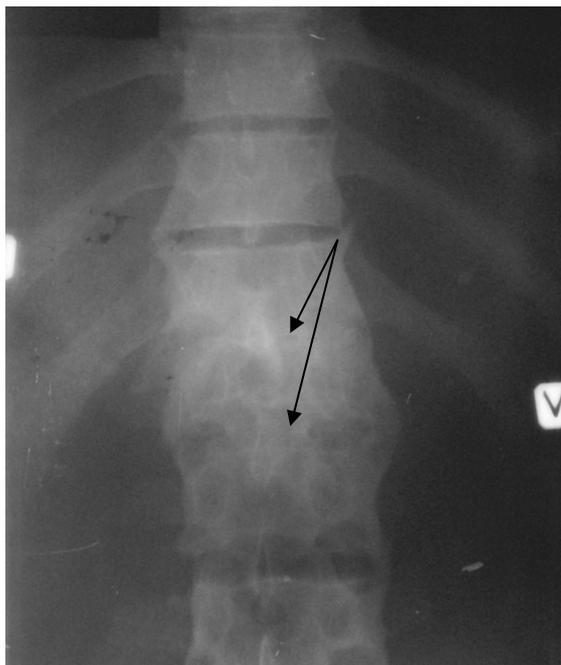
Enlargement radiograph of lumbar and chest departments of the backbone in a direct projection. Ankylosis Th12, L1 and L2 of vertebrae (arrows) is detected.
